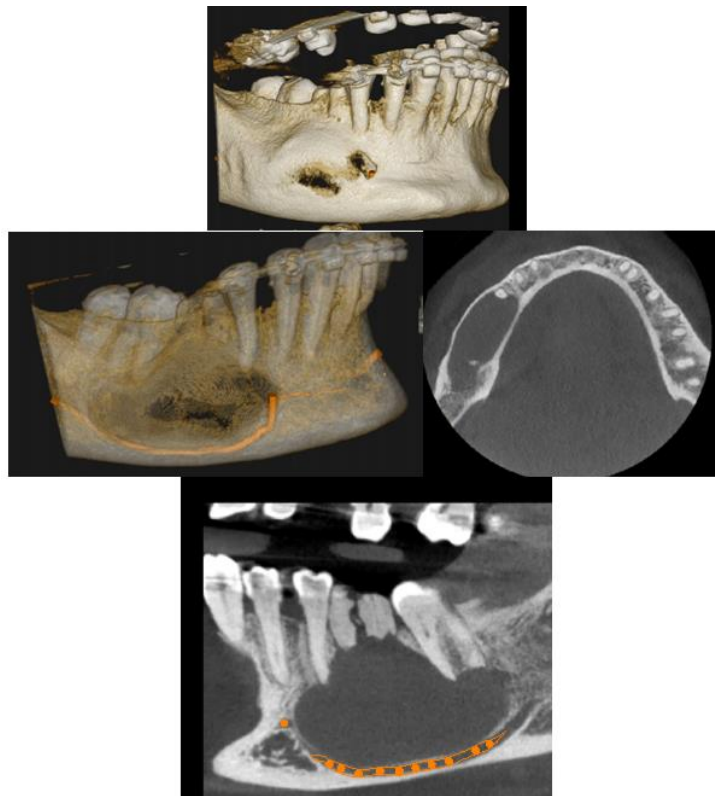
Reconstructed Panoramic Image with CBCT Scan
